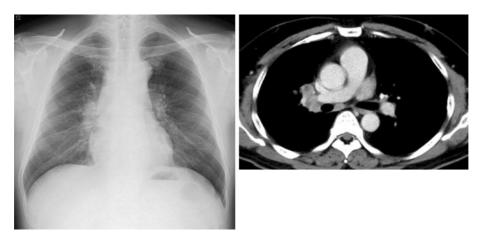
Chest X-ray and CT performed at the onset of symptoms. Chest X-ray revealed right hilar lymphadenopathy. CT showed right hilar and mediastinal lymphadenopathy. In each imaging study, no intrapulmonary lesions were noted.
